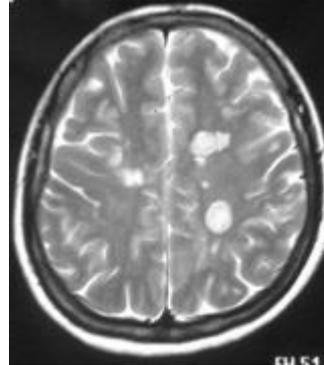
Brain MRI, T2-weighted sequences showing multiple hypersignals in centrum semiovale and cortex
